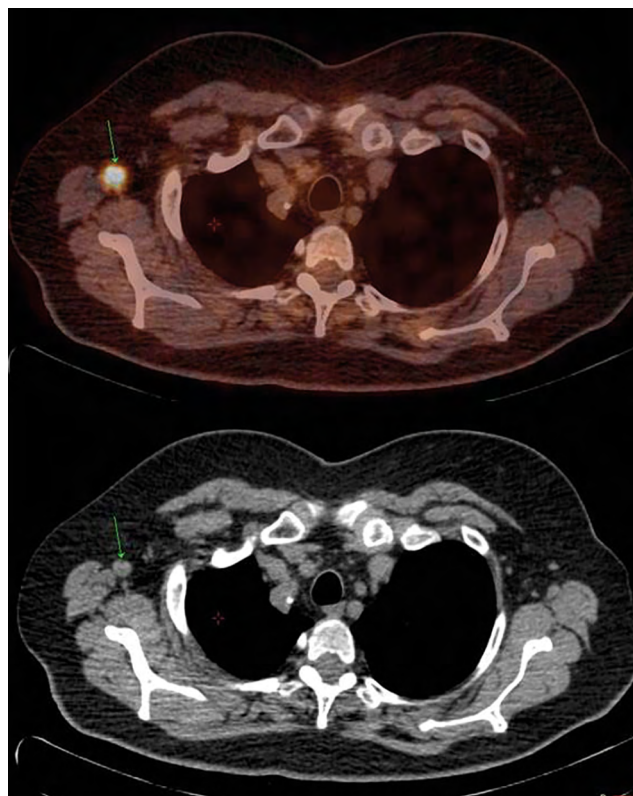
A patient with a right arm MM, stage at diagnosis pT4b NOM0. The patient had a recurrent in-transit lesion, treated surgically. Ten months after the recurrence, an axillar LN appeared, with a fatty hilum and diameter below 10 mm — negative in conventional studies. [¹⁸F]FDG PET/CT demonstrated a definite metastatic lesion with high FDG uptake, proven malignant after the operation
